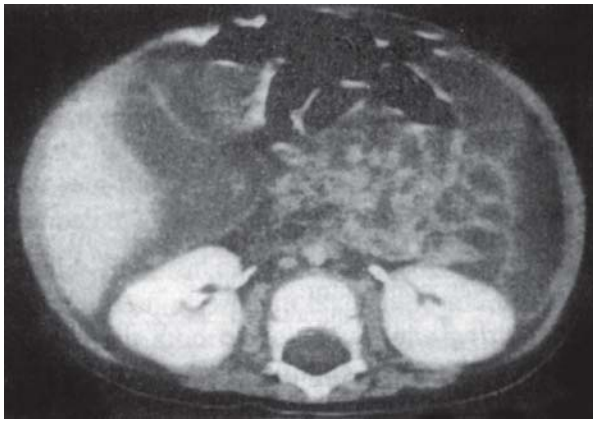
CT scan abdomen. Note the gross thickness of the intestinal wall with retention of a large amount of fluid
